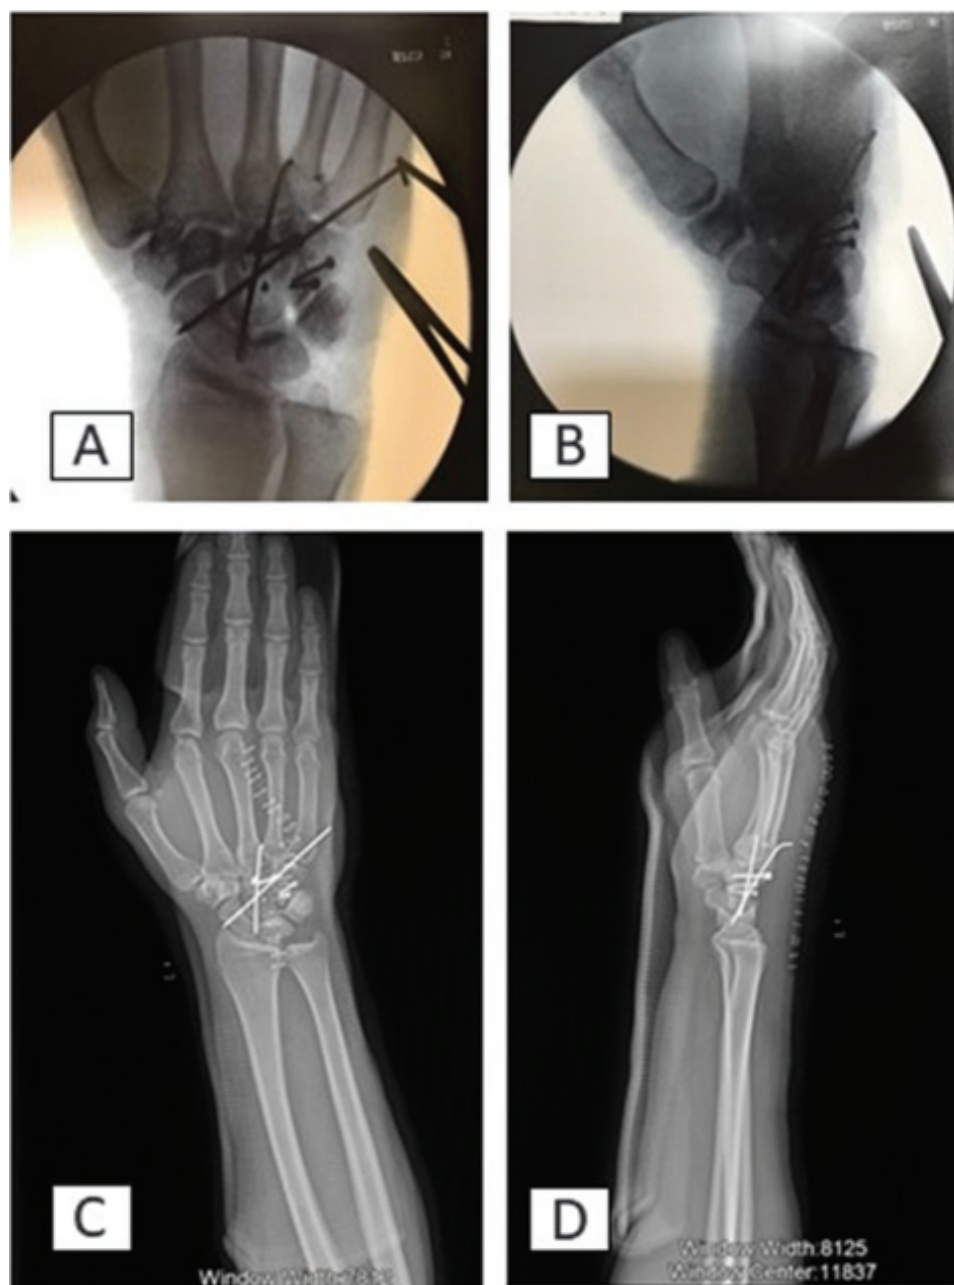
A & B. Intraoperative fluoroscopy images. C & D. Immediate post-operative radiographs (AP and Lateral).
